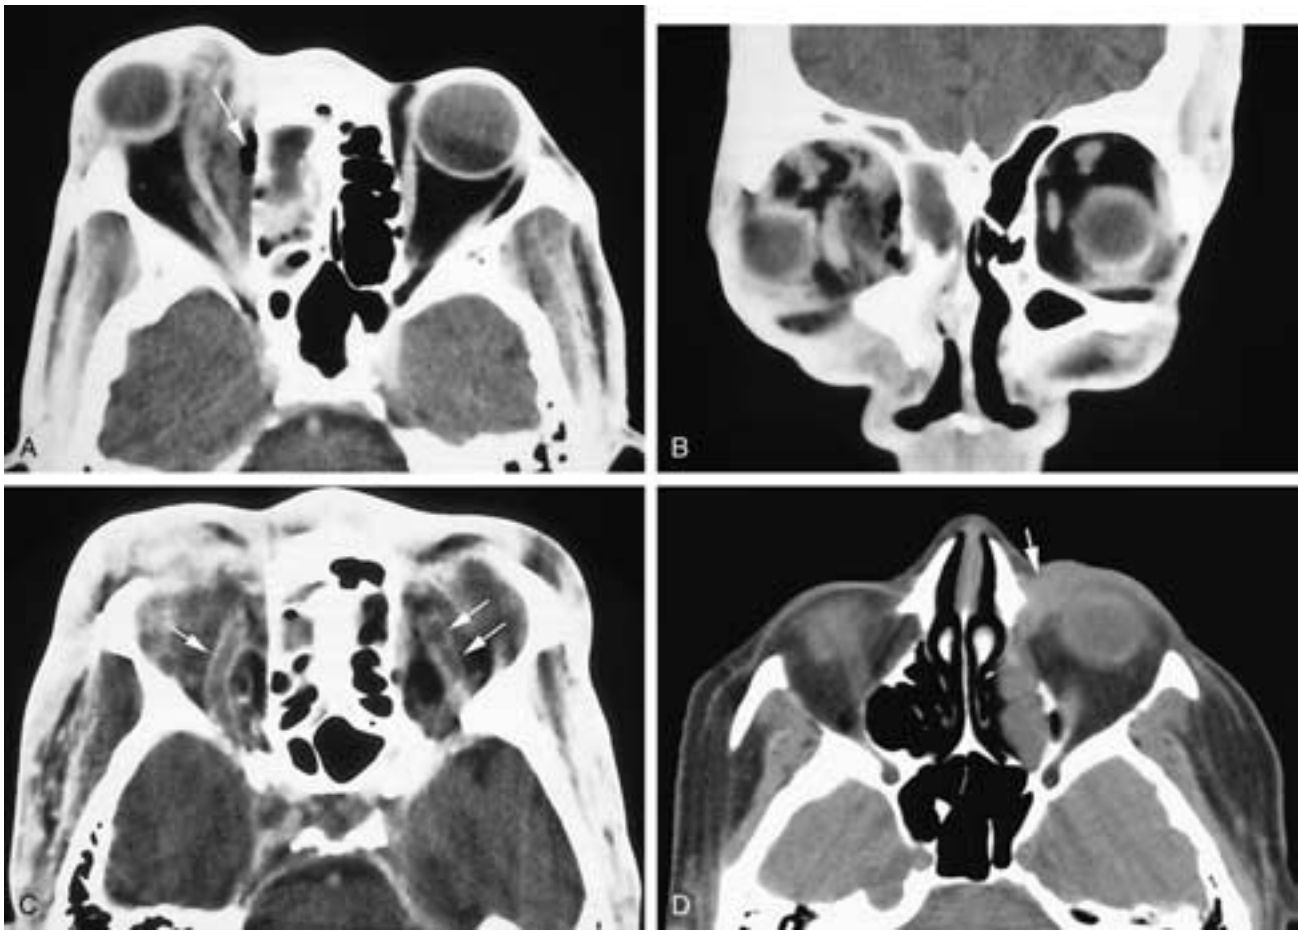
Axial (A) and coronal (B) contrast-enhanced CT scans on a patient with a right ethmoid sinusitis, a right orbital cellulitis, and air in an abscess (*arrow*). The globe is proptotic and laterally displaced. There is no gross defect in the right lamina papyracea. In C, a patient developed a right orbital cellulitis secondary to a right ethmoid sinusitis. The infection spread via the right superior ophthalmic vein (*arrow*) to the cavernous sinus, across the sella's vascular bed to the left cavernous sinus, and then retrograde into the left orbit via the left superior ophthalmic vein (*arrows*). In D, there is a left ethmoid sinusitis that spread through the lamina papyracea into the left lacrimal saccular area (*arrow*) and presented clinically as an acute dacryocystitis. This is a case of pseudodacryocystitis secondary to an ethmoid sinusitis.
